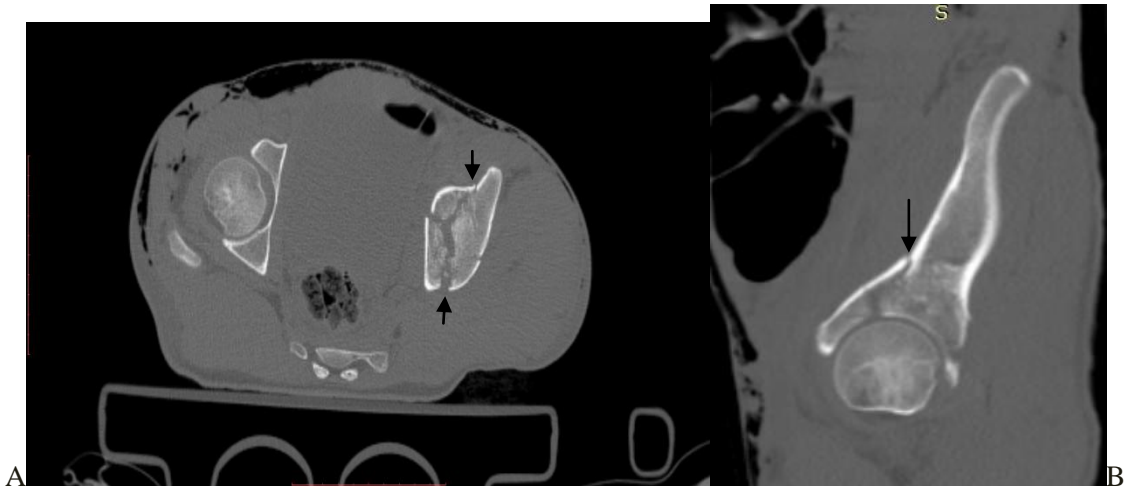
Left Anterior column with posterior hemi transverse acetabular fracture .Axial (A) and sagittal (B) pelvic CT scan of 20 years old male patient sustained RTA shows coronal fracture line(large arrow) involving the left acetabular anterior column with associated fracture extension to the acetabular roof. Associated sagittal fracture line (small arrow) involving the left acetabulum also noted. Associated subcutaneous emphysema also noted
